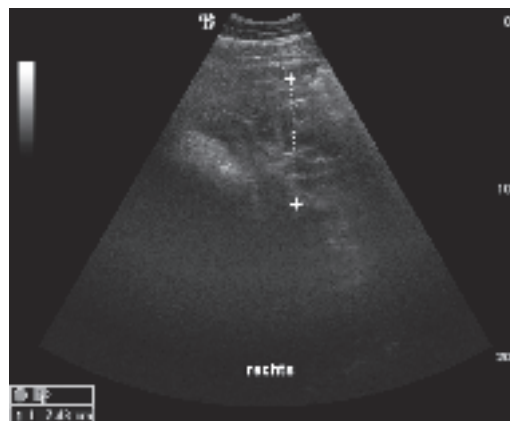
Intercostal ultrasonographic view of the right thorax, with dorsal to the right. A mass was present in the right ventral pleural space with a similar irregular shape and anechoic areas within the mass. This mass was more rounded in shape and the anechoic areas were increased in size. *Rechter Thorax: interkostale Ultraschallansicht, rechts ist dorsal. Eine Masse mit einer ähnlichen unregelmäßigen Form und echoarme Bezirke innerhalb der Masse, war im rechten, ventralen Thoraxraum vorhanden. Diese Masse war mehr abgerundet und enthielt größere anechogene Gebiete.*
